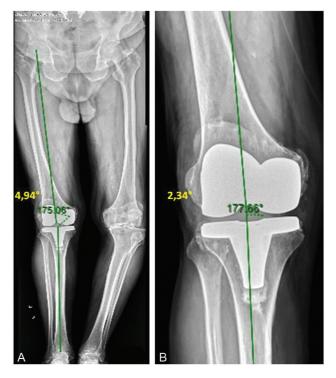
Comparison of femorotibial angle on long (A) and short (B) postoperative radiographs.
